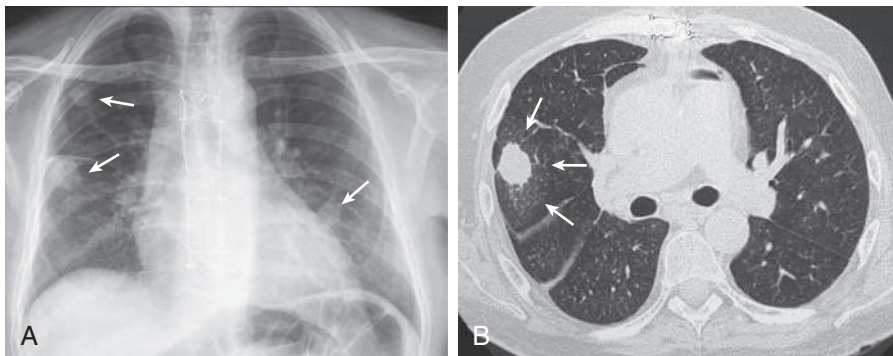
Angioinvasive aspergillosis. A, Posteroanterior radiograph shows multiple nodules in the lungs (arrows). B, CT section at the level of the intermediary bronchus shows a nodule surrounded by a halo of ground-glass attenuation (arrows). (From Franquet T. Nonneoplastic parenchymal lung disease. In Haaga JR, Boll DT, eds. CT and MRI of the Whole Body, 6th ed. Philadelphia: Elsevier; 2017. Fig 36.13.)
